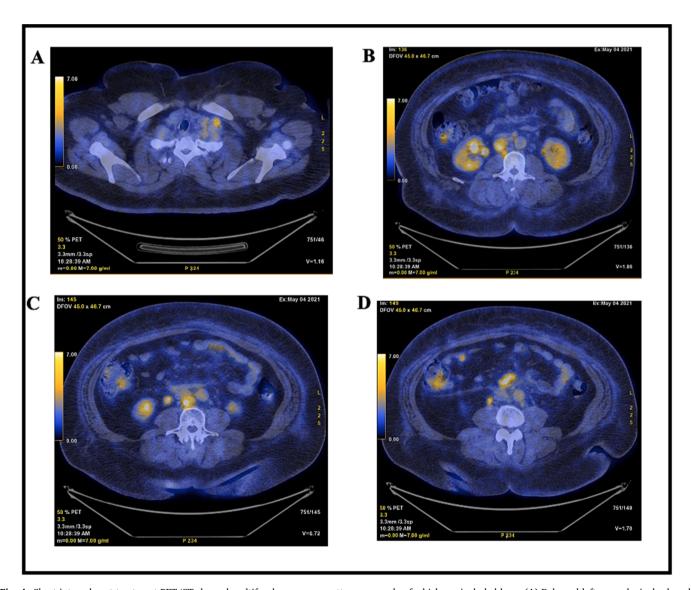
Short-interval post-treatment PET/CT showed multifocal recurrence pattern, a sample of which are included here. (A) Enlarged left supraclavicular lymph node measuring 1.9×1.2 cm with SUV max of 5.2 (B) Right retrocaval lymph node measuring 1.9×2.3 cm with SUV max of 8.4, previously 1.2×1.3 cm with SUV max of 3.7 (C) New aortocaval node measuring 2.2×1.5 cm with SUV max of 8.6. (D) Mesenteric soft tissue nodule measuring 3.5×1.6 cm with SUV max of 8.2, previously 1.5×1.2 cm with SUV max of 5.9. There is surrounding misty mesentery.
